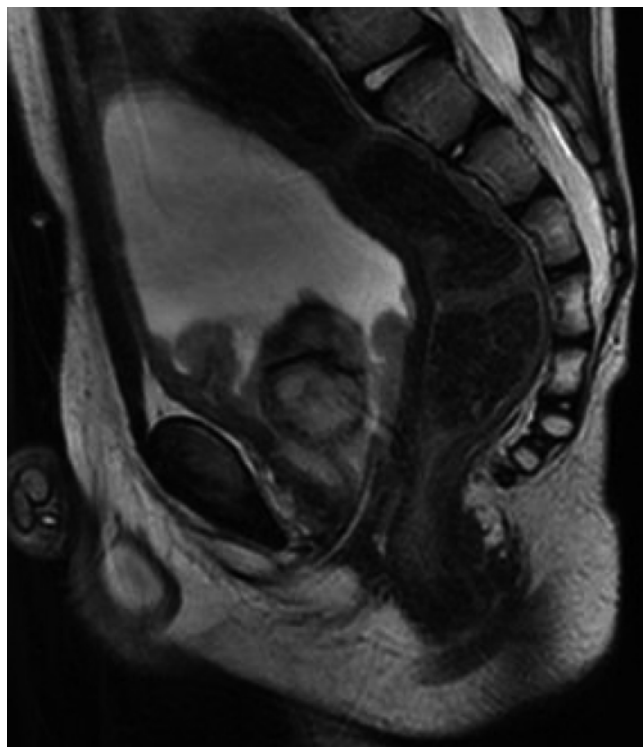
Bladder RMS at diagnosis in a 4 year-old boy (T2 weighted MRI)
